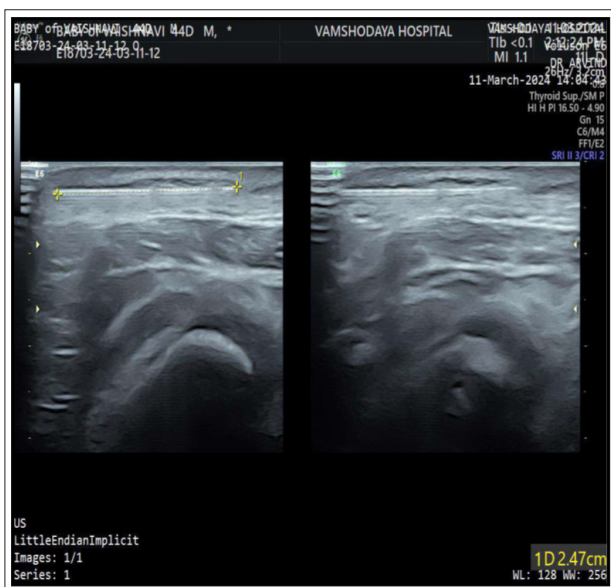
Ultrasonography showing the foreign body in subcutaneous plane
